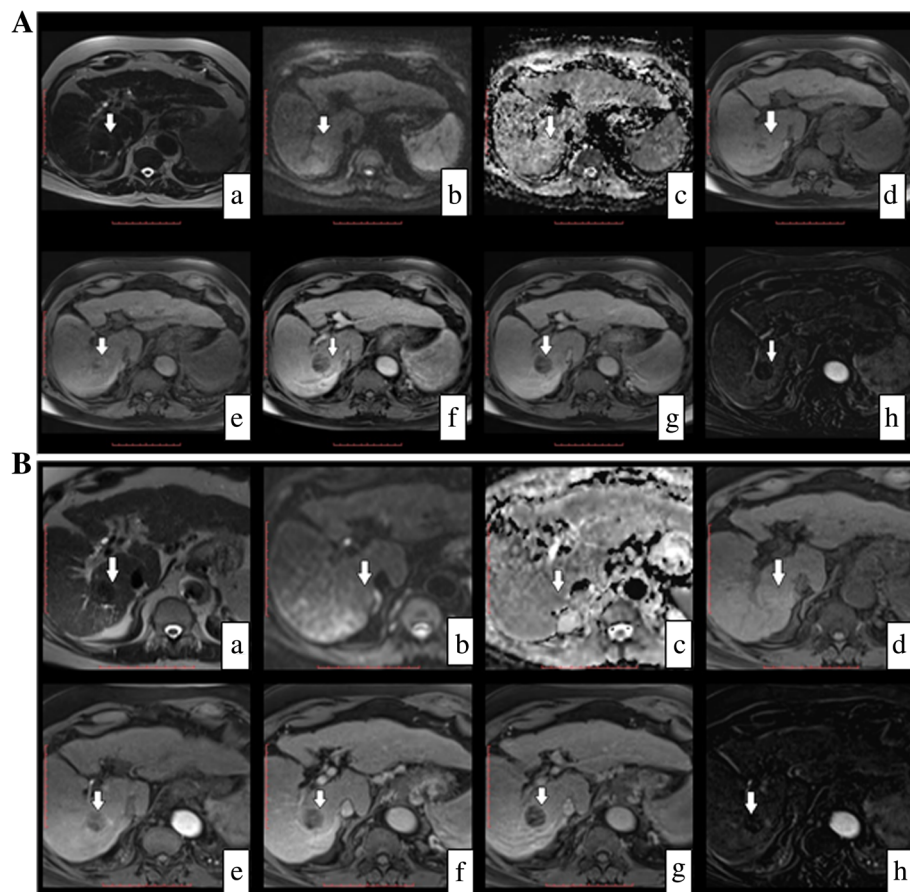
A 70-year-old male patient with hepatitis-related liver cirrhosis and single segment V/VI HCC lesion. He had a TACE session and came for follow up 1 month later. (A) Follow up dynamic MRI 1 month post TACE. a T2WI, b DWI image, c ADC image, d T1WI, e late arterial phase, f portal phase, g delayed phase, and h late arterial subtracted image. The treatment zone elicits low to isointense signal in T2WIs, and iso to high signal in T1WIs. It measures about 3.4×2.4 cm in diameter with high central signal in the arterial phase worrisome for residue. ADC value measured (1.3×10^{-3} mm²/s). Subtraction removed the central high signal thus excluding residual disease (false positive dynamic study interpretation). (B) Follow up dynamic MRI 3 months post TACE. a T2WI, b DWI image, c ADC image, d T1WI, e late arterial phase, f portal phase, g delayed phase, and h late arterial subtracted image. Regression in the size of the treatment zone with still no contrast uptake confirming the complete response
